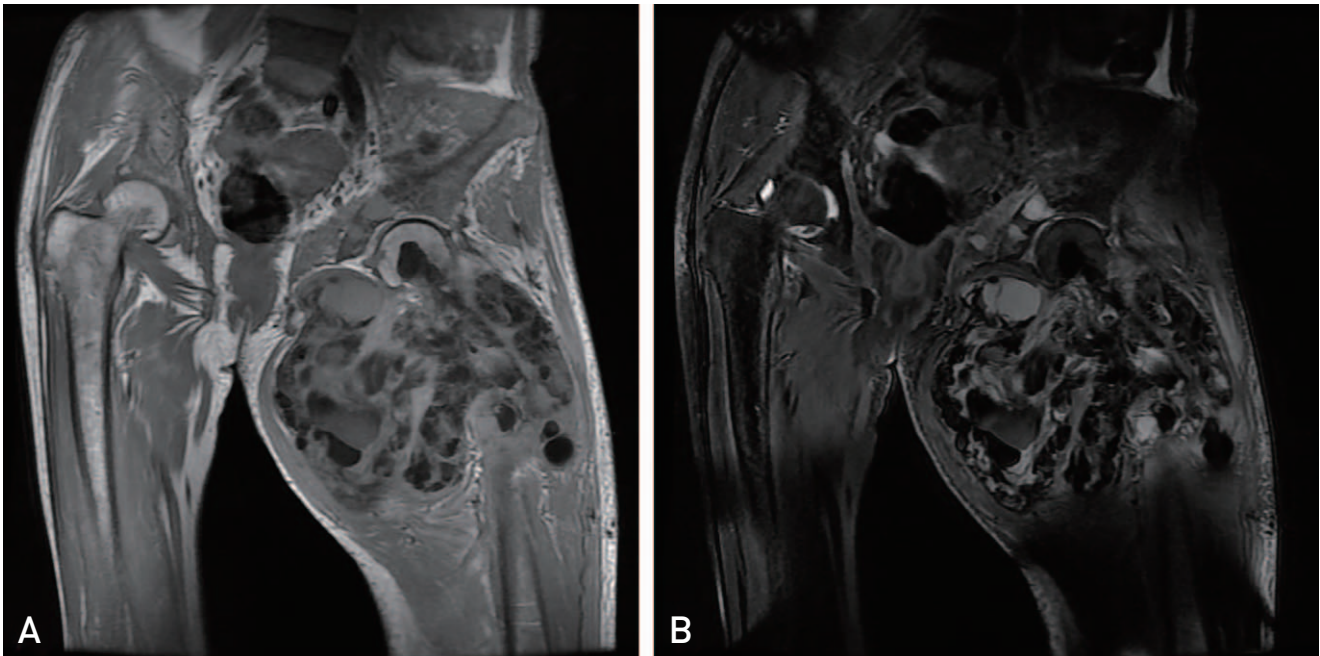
Preoperative coronal view of magnetic resonance imaging. (A) T2-weighted sequence of the pelvis. (B) T1-weighted sequence of the pelvis. The lesion had in-homogeneous high-signal intensity with T2-weighted image and in-homogeneous low signal with T1-weighted image. It showed bony invasion of tumoral calcinosis in the femoral neck.
